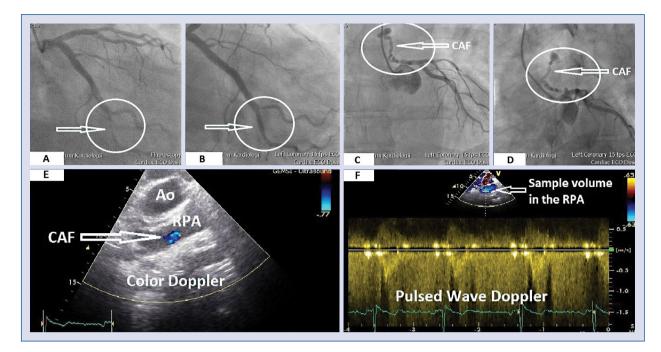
A. Coronary angiography: critical stenosis of the marginal branch (arrow); B. Coronary angiography: successful percutaneous coronary intervention of marginal branch (arrow); C, D. Coronary angiography: coronary artery fistula (CAF; arrow); E. Echocardiography study — suprasternal view of long axis of right pulmonary artery (RPA) — color flow Doppler images: CAF flow (arrow); F. Echocardiography study — suprasternal view of long axis of right pulmonary artery (RPA) — pulsed-wave Doppler: CAF flow (arrow) — sample volume in the RPA; Ao — aortic arch.
